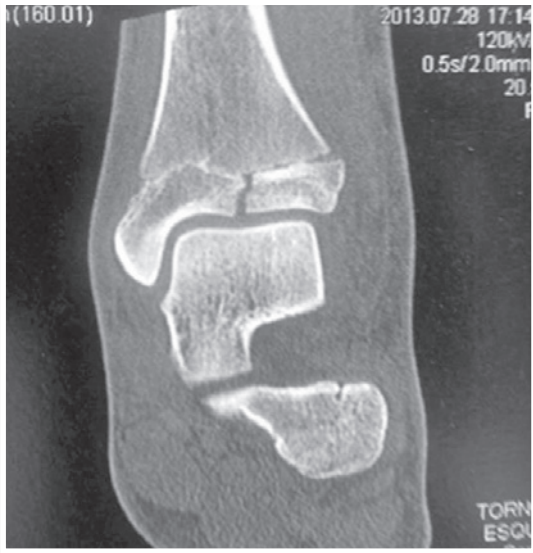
Computed tomography, sagittal slice.
